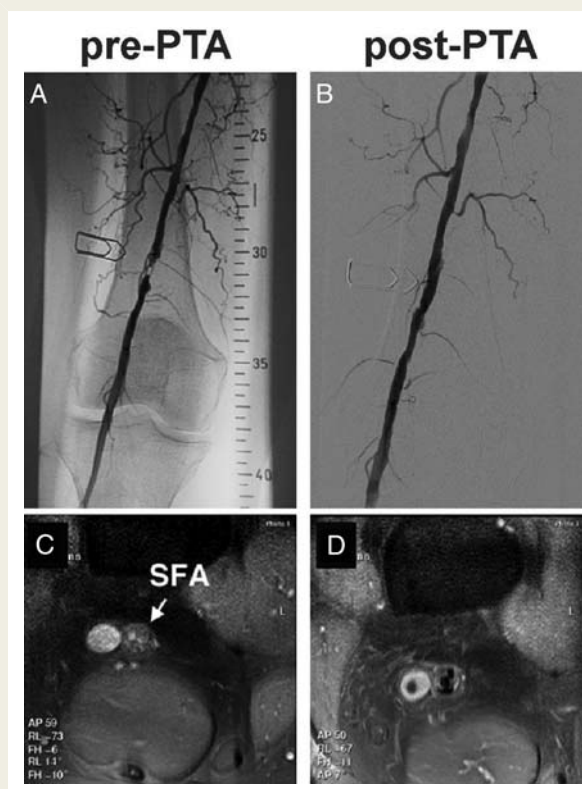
Effect of percutaneous transluminal angioplasty on severe femoral stenosis. Angiography (upper panel) and high-resolution magnetic resonance imaging (lower panel) before and after percutaneous transluminal angioplasty. SFA, superficial femoral artery.
